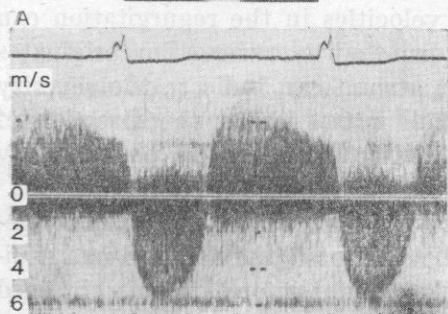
Aortic stenosis and regurgitation recorded with CW Doppler from the apex, aortic flow is away from and regurgitation is toward the transducer. In *A* the obstruction is severe with a calculated peak pressure drop of 125 mm Hg, and the velocity stays high during most of systole. In *B* obstruction is insignificant, the calculated peak pressure drop is 34 mm Hg, but the velocity decreases rapidly and is low in late systole showing almost equalization of left ventricular and aortic pressures. Note difference in scale from *A* to *B*. Velocity in aortic regurgitation is high due to the pressure difference between the aorta and the left ventricle in diastole, and velocity decreases as aortic pressure falls. The amplitude curve below the phonocardiogram in *B* shows aortic valve opening and closure. Forward and regurgitant flows are continuous. Note the concentrated band of the high frequencies in the aortic stenosis in *A* which indicates that the jet is well recorded
